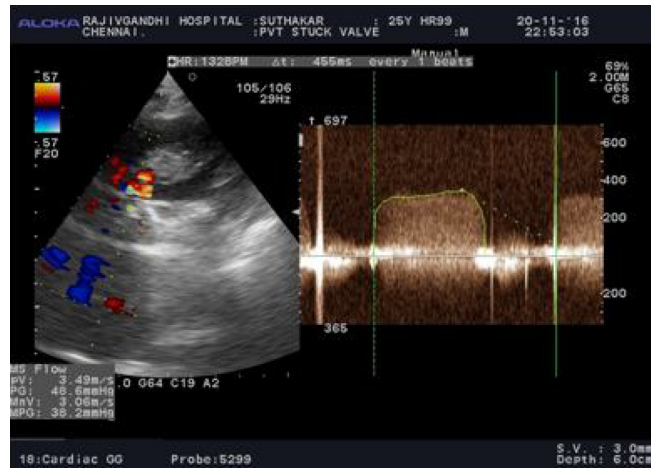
Continuous Doppler across the mitral prosthesis of patient shown in Fig. 1: Peak PG was 48.6 mmHg and mean PG was 38.2 mmHg.
